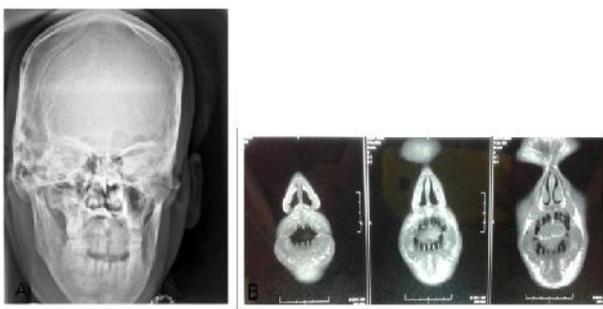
(A) PA skull showing no significant radiographic findings. (B) MRI scan showing significant swelling of lower lip with enhanced soft tissue within on post contrast examination
